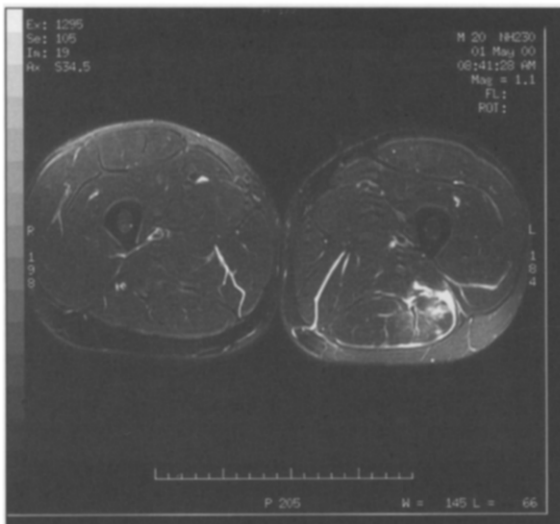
MRI positive scan of a double muscle injury involving proximal BF/ST.
